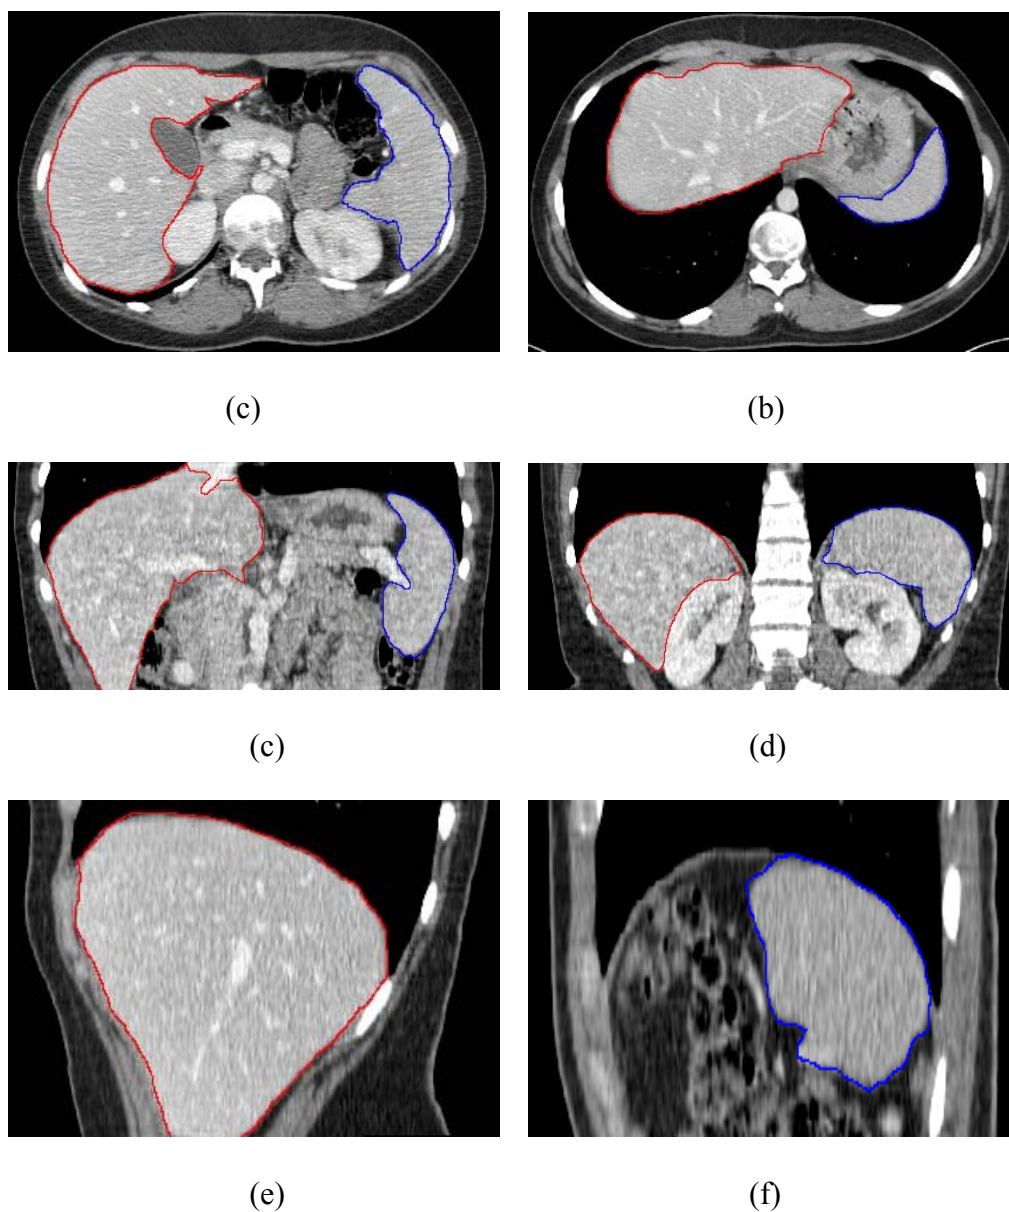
CT image examples acquired for the evaluation of a liver transplantation donor (liver: red, spleen: blue) (a) Axial image (original slicing axis), it is clear that the liver and spleen have the same density distribution and texture (b), (c) Reconstructed coronal images where liver and spleen appear together (d), (e) Reconstructed sagittal images where liver appears and ends before the spleen.
